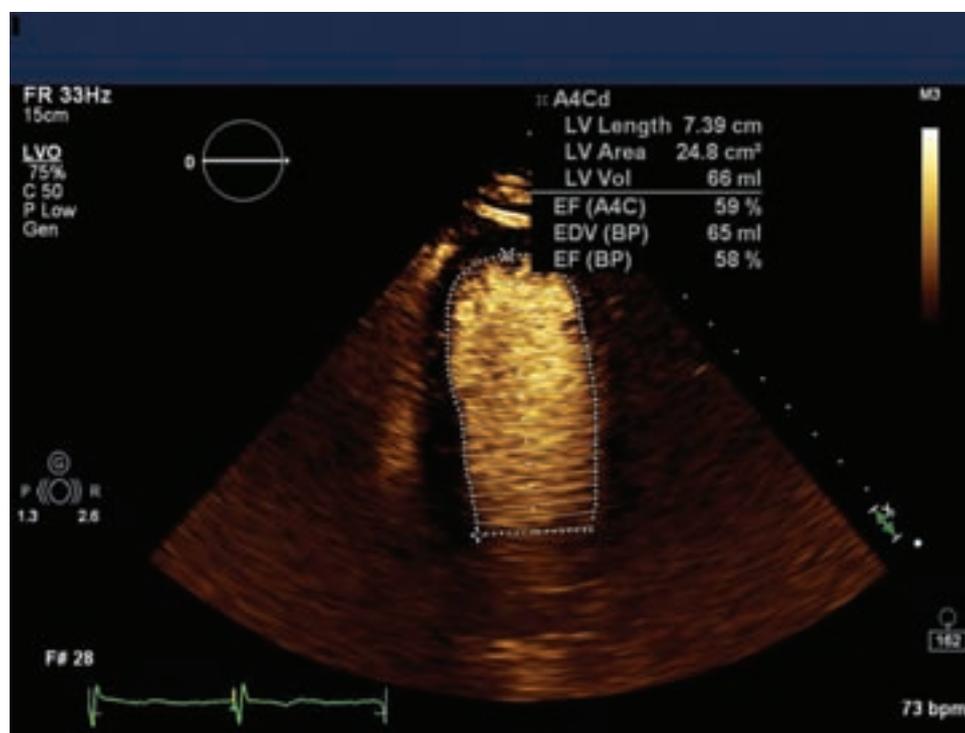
End-diastolic endocardial tracing obtained from the apical four-chamber view after the administration of contrast for the calculation of LVEF using the method of disks in a patient with inadequate 2D echocardiographical images.
